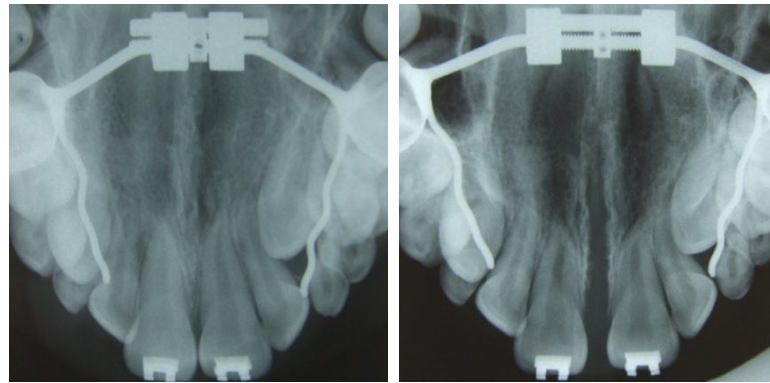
Occlusal radiographs before RME (left) and after RME (right), showing the opening of the midpalatal suture
